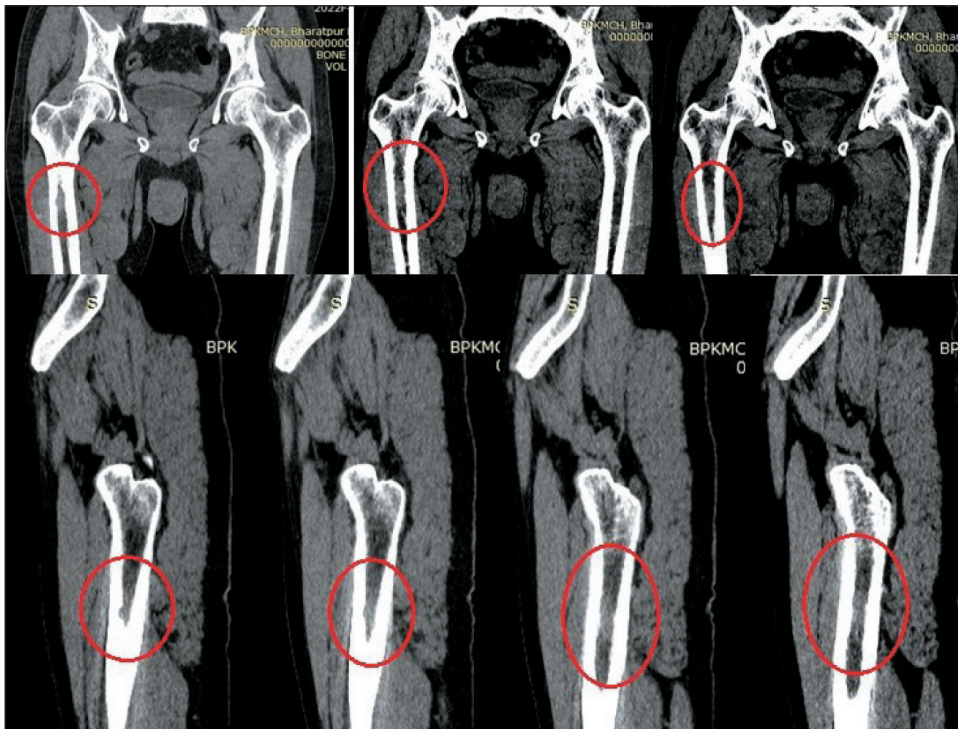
There is metastatic like lesion in right proximal shaft of femur just below the neck in CT scan of Pelvis & Thigh and there are also bilateral inguinal lymph nodes metastases. Note: created by the authors
